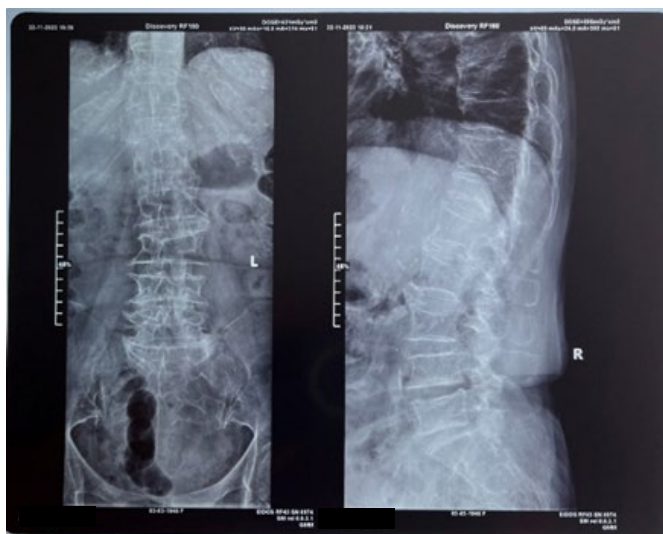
The X-ray examination of the lumbar spine (anterior and profile): diffuse bone demineralization, osteosclerosis of the vertebral plateaus, levoconvex lumbar scoliosis and dextroconvex thoracic scoliosis, multiple vertebral compressions predominantly at the level of the T12, L3, L4 vertebrae, narrowing of the intervertebral space L4-L5, lateral and anterior osteophytes, calcification of the abdominal aorta
